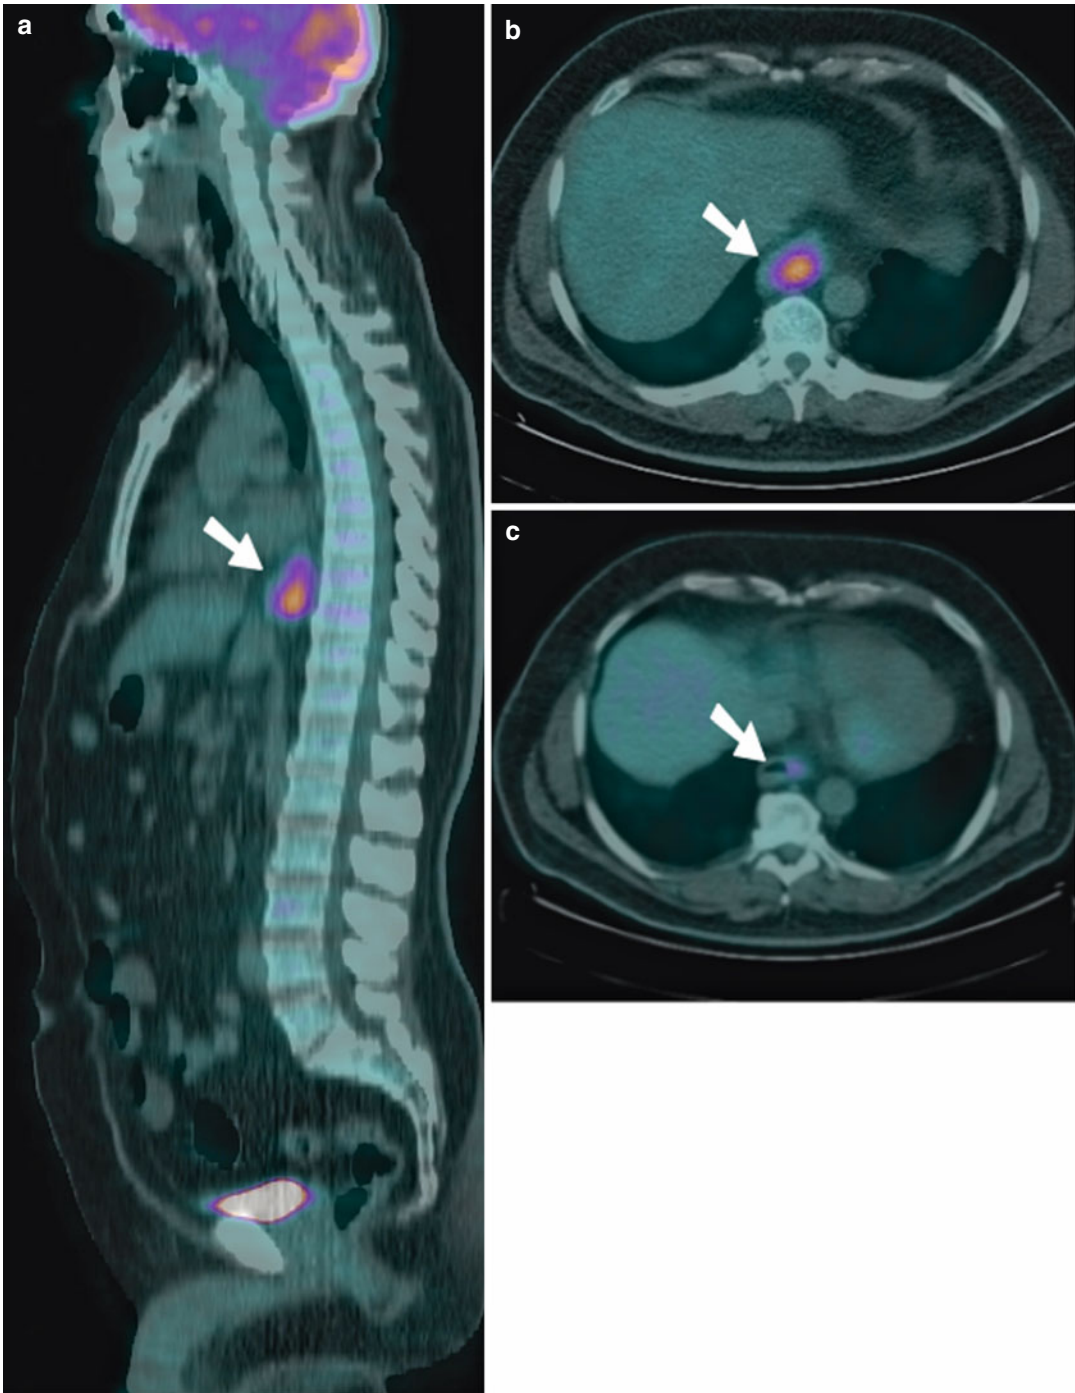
(a) Sagittal and (b) axial staging FDG PET-CT images of a 59-year-old man with newly diagnosed squamous cell carcinoma of the distal thoracic oesophagus (arrows). The primary demonstrated intense focal FDG uptake with a SUV_{max} of 8.6. No other sites of disease were identified on PET. He underwent three cycles of neoadjuvant chemotherapy, and a follow-up scan was undertaken to assess treatment response.
